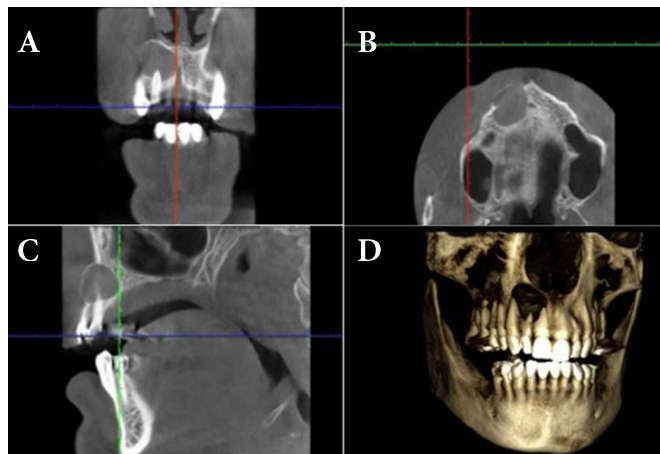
A) Coronal view of CBCT revealed a well-defined, large, unilocular, periapical radiolucency with narrow cortical borders; B) Axial view revealed buccal cortical plate perforation; C) Cortical expansion and perforation were obvious in sagittal view, but no perforation was observed neither in the floor of the nasal bone nor in the palatal cortical bone; D) CBCT volumetric rendering showed buccal cortical plate perforation, no root displacement or resorption was present
